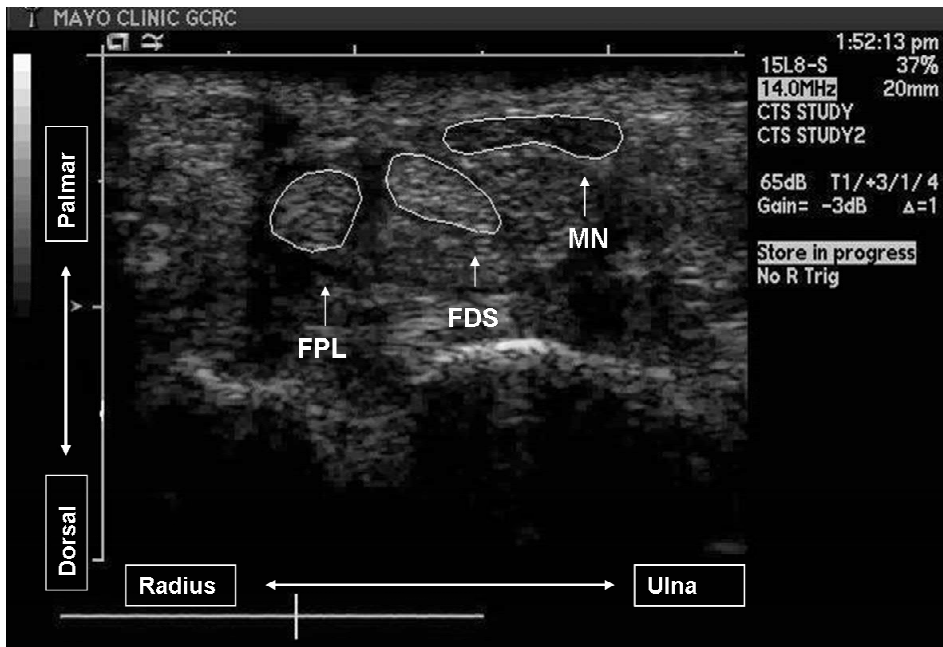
• Cross-sectional ultrasound image with outlined median nerve, index finger FDS and FPL tendon. FPL = flexor pollicis longus.
